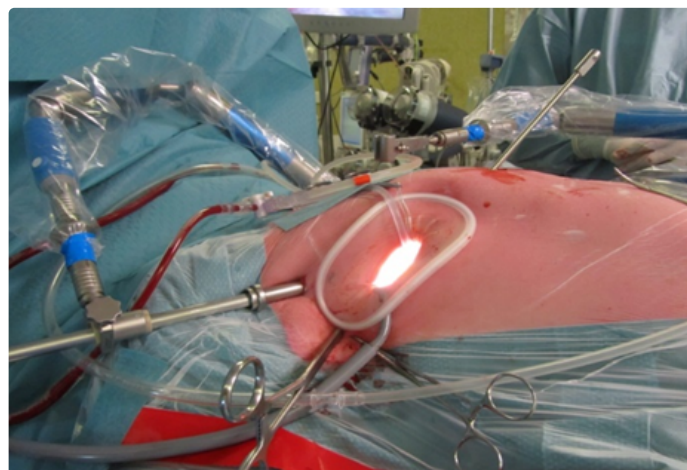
Setup of a MIMVS procedure by right anterolateral mini thoracotomy. Starting from the bottom of the soft tissue retractor in clockwise direction: Carbon dioxide insufflator, Transthoracic Chitwood clamp, video port and left atrial retractor.
